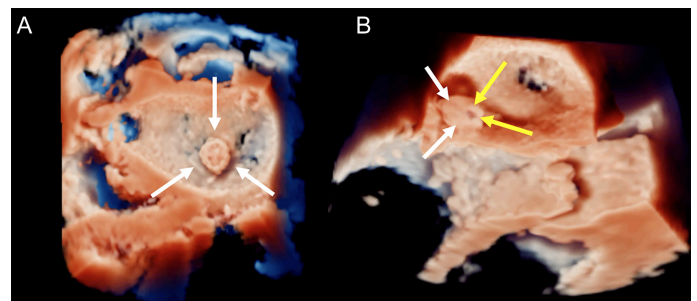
TrueVue 3-dimensional transesophageal echocardiography displaying aneurysm of anterior mitral leaflet (A) and its ruptured site as a hole (B). White arrows indicating aneurysm of anterior mitral leaflet; yellow arrows indicating a hole on the aneurysmal wall.
